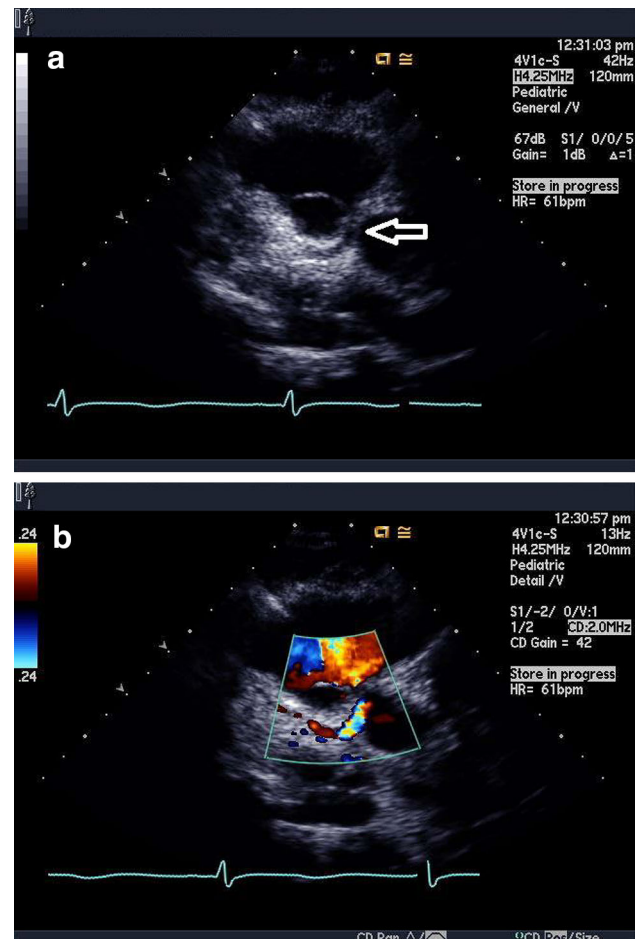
Parasternal long axis evaluation of anomalous left coronary artery in the same patient with the anomalous course identified in a 2D (arrow) and b color Doppler (blue)
